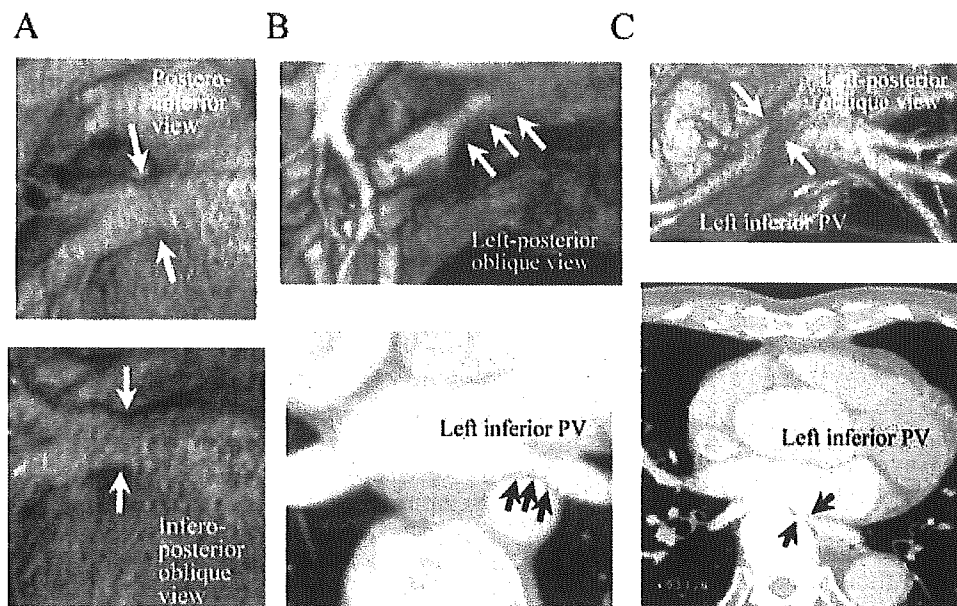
(A) Volume rendering images of the left inferior pulmonary vein (PV) in a patient with atrial fibrillation before ablation. The arrows indicate a narrowing of the vein (27% luminal reduction). (B) A volume rendering image postprocessing cutting the descending aorta (upper panel) and curved MPR (lower panel) of the left inferior PV before ablation. Dominant luminal reduction on the posterior side is shown. (C) A volume rendering image of the left inferior PV postprocessing cutting the spine (upper panel) and axial cross-sectional CT image (lower panel) in a control patient. The arrows indicate the narrowest portion of the vein (66% luminal reduction). A narrowed and kinked left inferior PV, positioned between the left atrium and the spine, is shown (black arrows).
